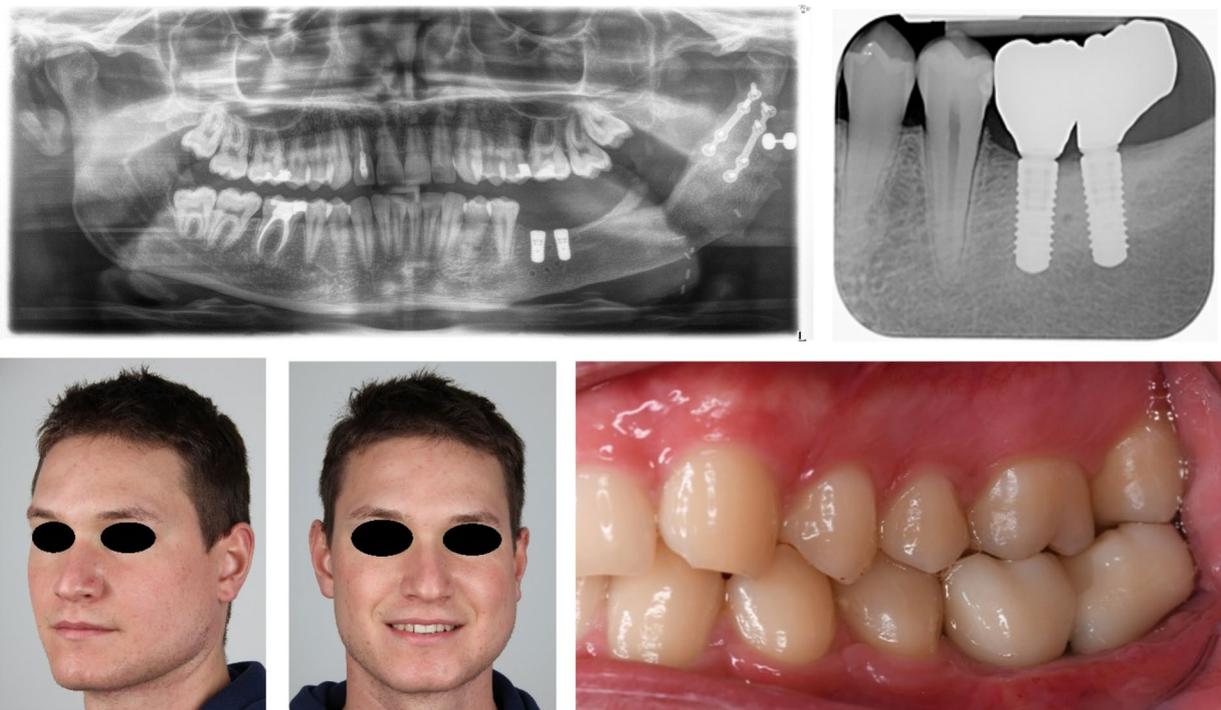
Upper left: orthopantomogram after reconstructive surgery (keratocyst diagnosis); upper right: X-ray after dental implant placement; lower left: en face pictures of the patient after reconstructive surgery; lower right: postoperative outcome after dental rehabilitation
